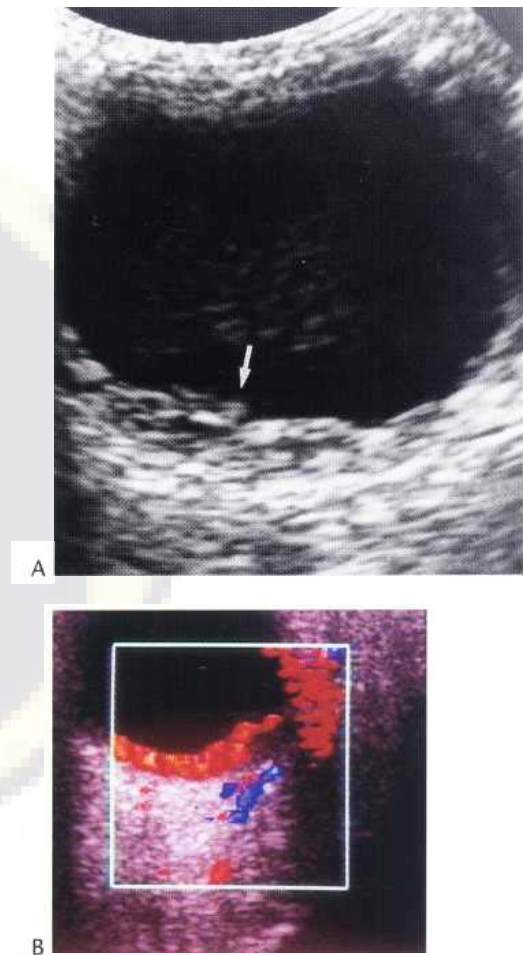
(A) Choroidal metastases (arrow). Vertical scan. (B) Colour Doppler scan.
